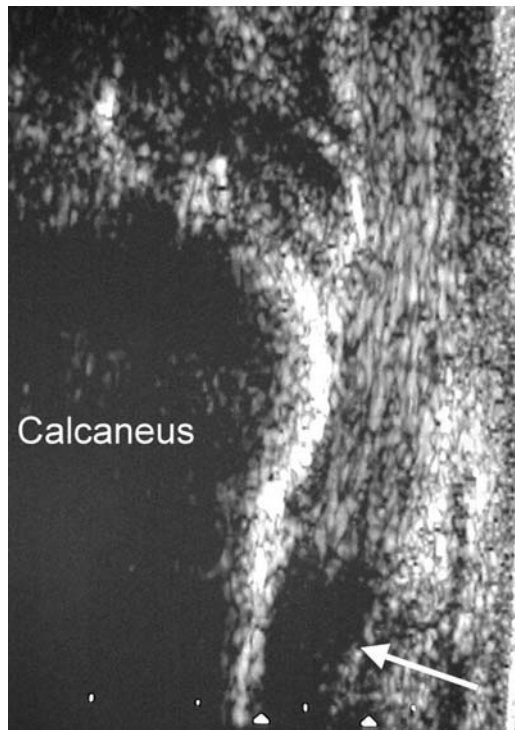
Non compound sagittal ultrasound of Achilles tendon showing anisotropic artifact at the insertion onto the calcaneus (arrow).
